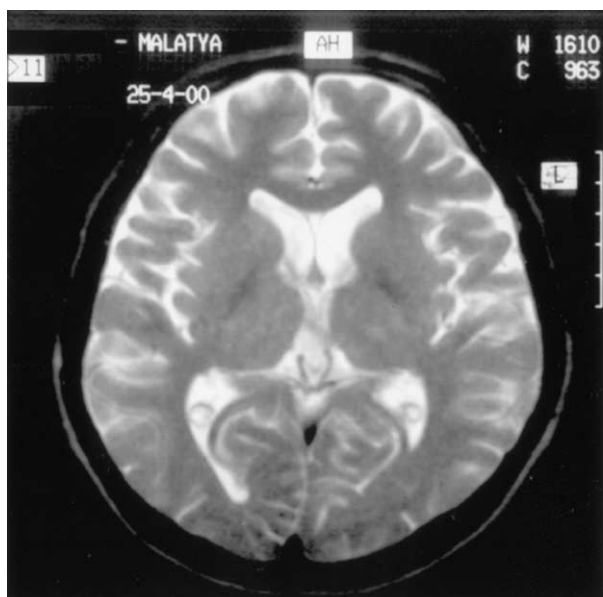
MRI did not show any pathological finding at the level of basal ganglia.
